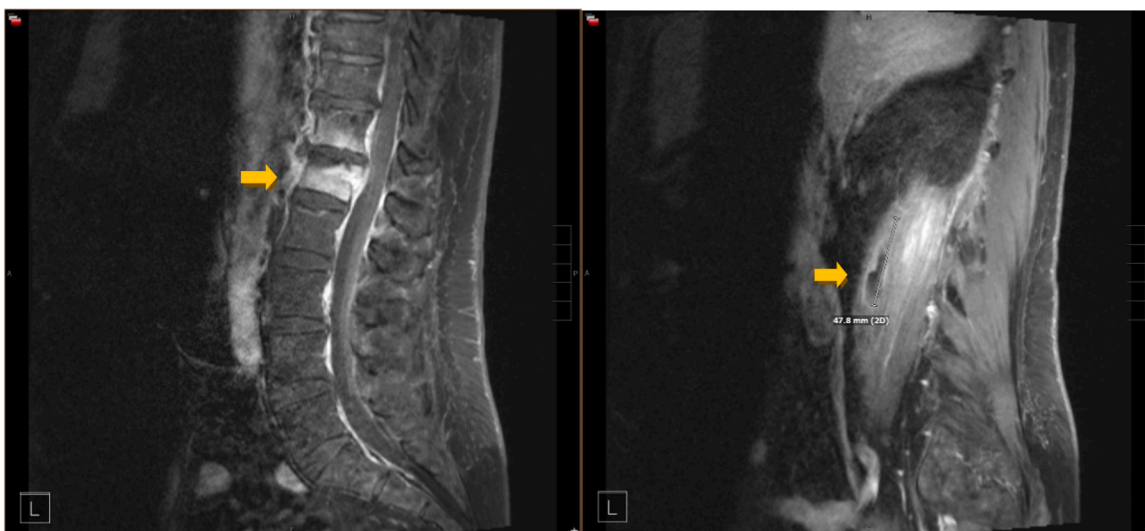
Magnetic resonance imaging (MRI) of lumbar spine upon admission showed discitis-osteomyelitis at the T12-L1 level with mild compression fracture of the L1 vertebral body (left panel, denoted by yellow arrow); also noted were intramuscular abscesses within the right psoas muscle (right panel, denoted by yellow arrow).
